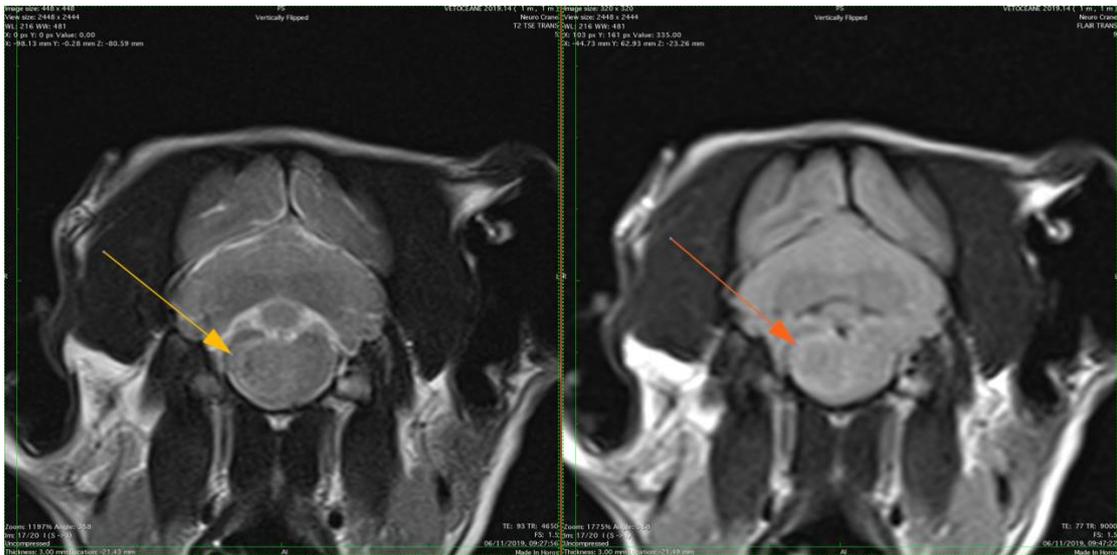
Trv T2W (left) and T2-FLAIR (right) pons
